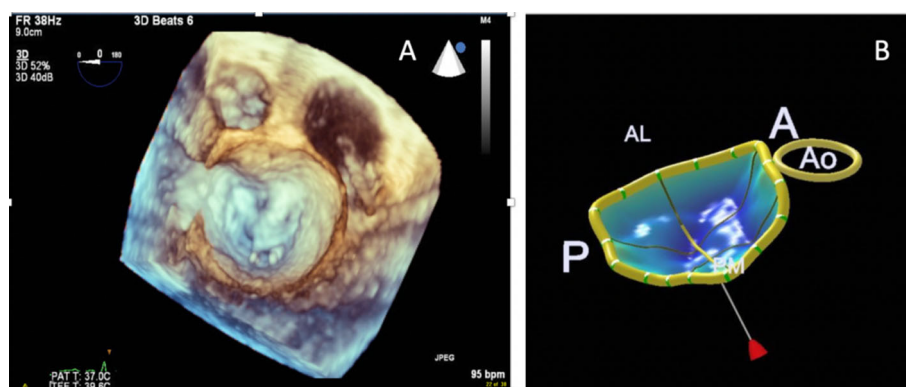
Multi-beat transesophageal 3D view of the mitral valve in en face “surgeons view”, showing a prolapse of the A2 scallop and flail chordae (A); mitral valve navigator model of the mitral valve allowing for complex measurements of the mitral valve apparatus (B)
